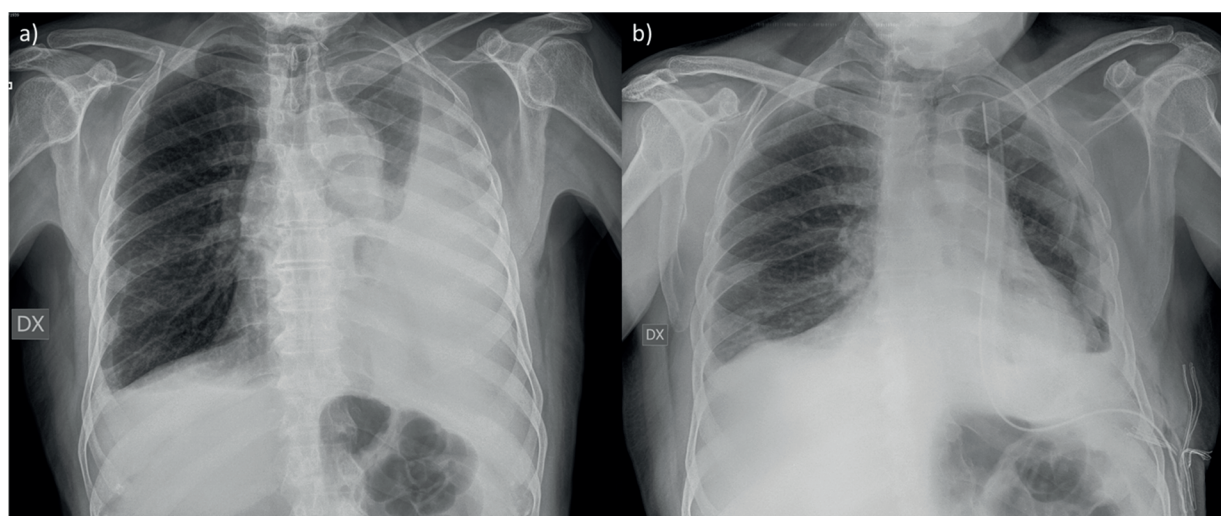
Chest X-ray of the same patient: in a) the chest X-ray was performed in Institute for the placement of a drainage pipe and in b) at patient home for a control.
